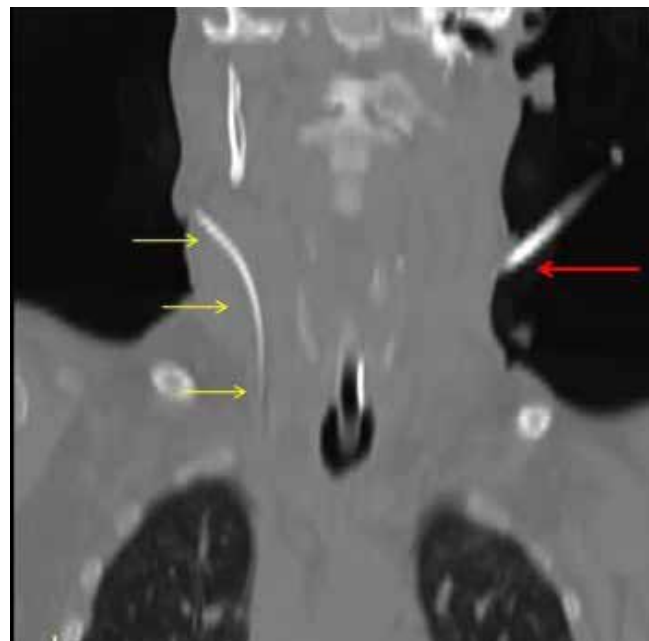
Coronal section CT image showing dialysis catheter (red arrows) and right internal jugular central venous catheter (yellow arrows).
